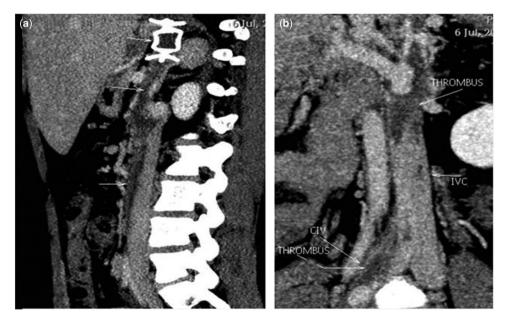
(*a*) CT contrast venogram showing thrombosis in the anomalous venous channel extending to the inferior caval vein (IVC). The vascular plug is seen in the anomalous channel. (*b*) Thrombus is seen in the inferior caval vein and common iliac vein (CIV).
